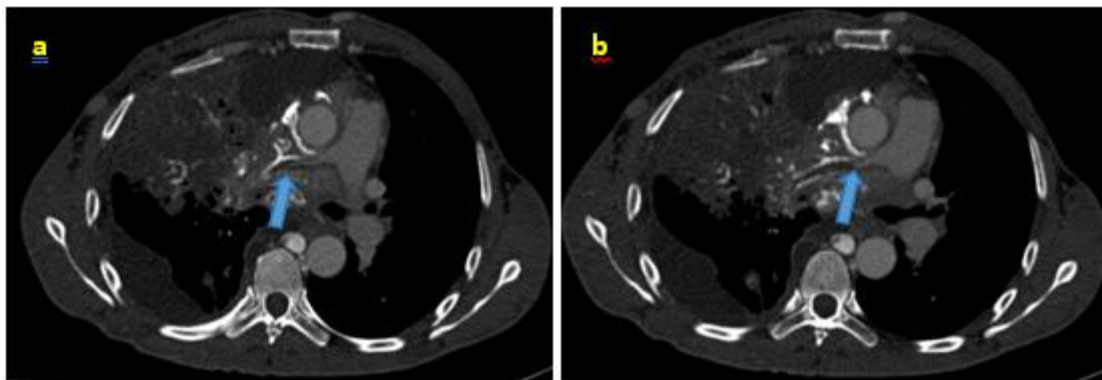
Contrast-enhanced thoracic CT demonstrating extensive infiltrative soft-tissue density within the mediastinum, encasing mediastinal vessels and tracheobronchial structures
